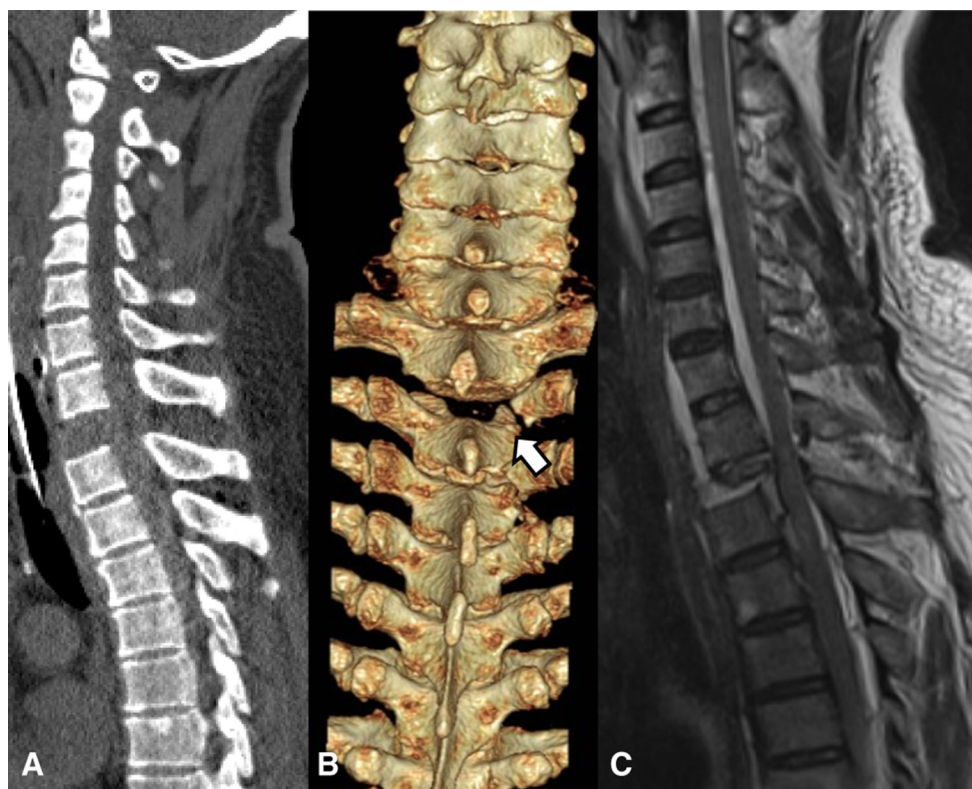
Radiological examination of the case shows a widening of the T1–2 disc space on the computed tomography scan. b Arrow indicated fracture of the T2 right transverse process and lateral half of the superior articular process seen in three-dimensional reconstruction
